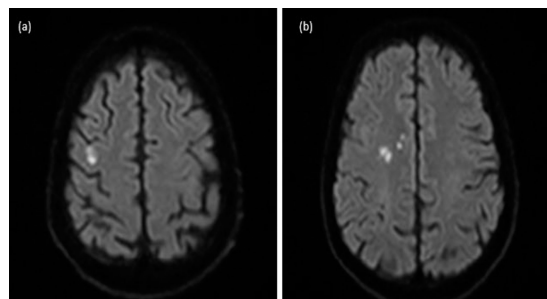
MRI brain demonstrating foci of restricted diffusion within the right frontal lobe (a) and the right frontal parietal cortical junction (B) on DWI sequence.
